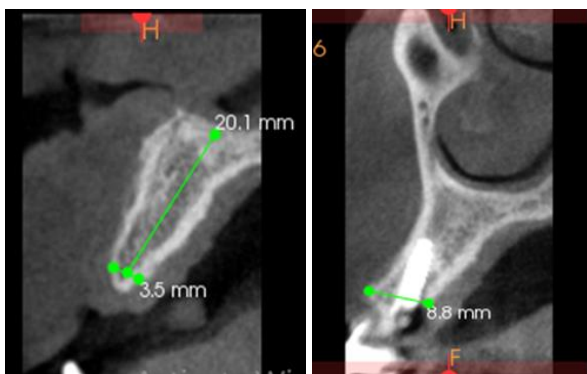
Preoperative CBCT ,9th Month Postoperative CBCT with Ridge width measurement
